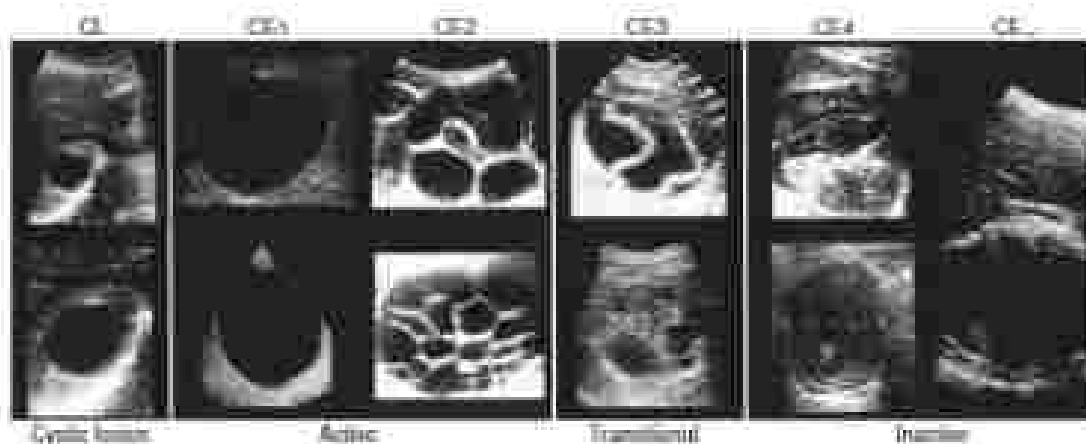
Ultrasound appearance of hepatic echinococcosis lesions. CE1, unilocular simple active cyst; CE2, unilocular simple active cyst with aniform anechoic content; CE12, multivesicular, multiseptated active cyst; CE13, unilocular transitional cyst; CE14, heterogeneous hyperechoic or hyperechoic, noncystic cyst; CE15, inactive cyst with thick calcified wall.
